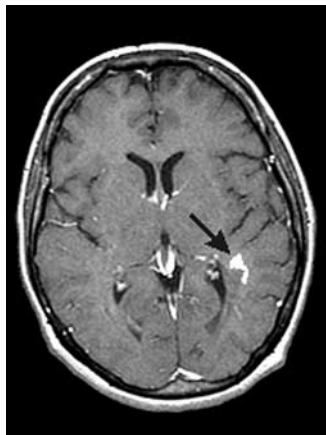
One section of the gadolinium-enhanced T1-weighted images from a patient with MS and the segmented enhancing lesion (arrow).
